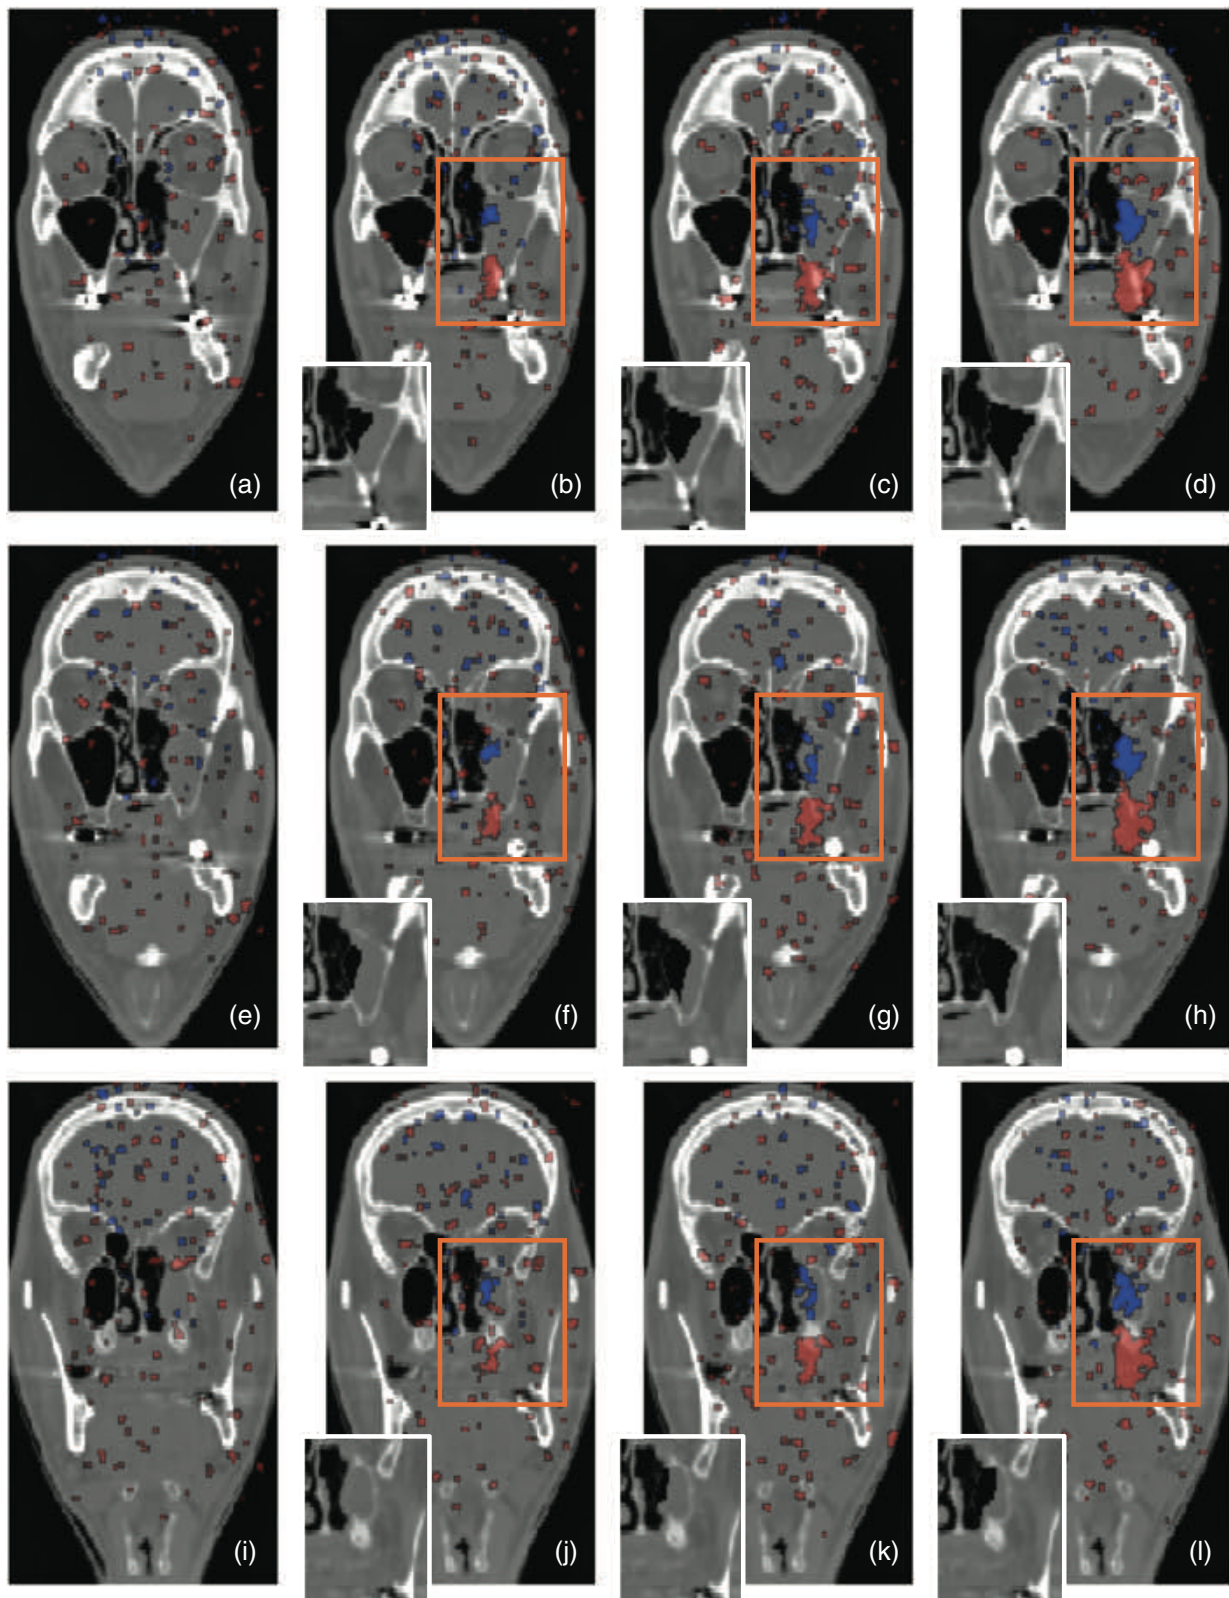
p -value maps for emptied volumes of 0.0 mL (a, e, i), 3.8 mL (b, f, j), 7.3 mL (c, g, k), and 13.1 mL (d, h, l). The upper, medium, and lower four plots correspond to a different CT slice. The small insets in the slices show the region that corresponds to the observed p -value map
